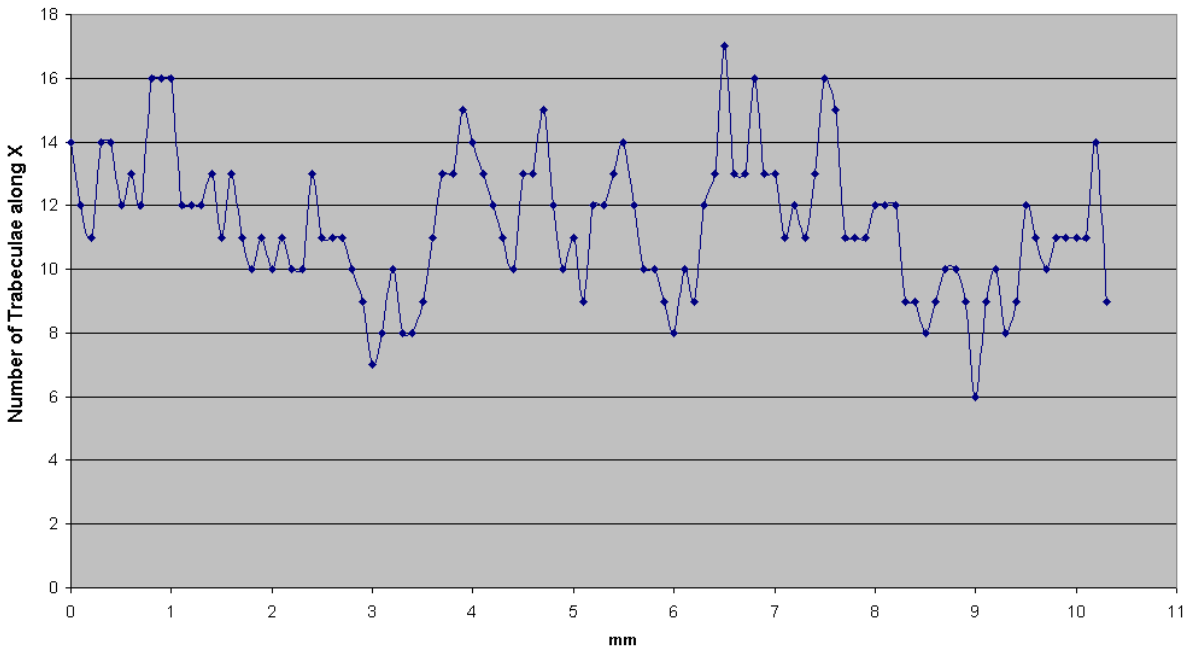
Cubic  $\mu$ CT sample: number of trabeculae along X
